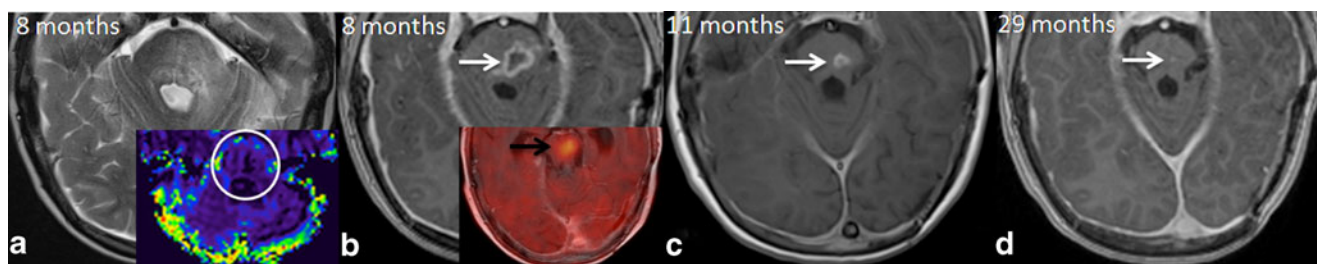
Follow-up MRI 8 months (a, b), 11 months (c), and 29 months (d) after beginning of complementary proton beam irradiation. a Axial T2-weighted showing an hyperintense lesion within the pons. b Axial T1-weighted after gadolinium showing appearance of abnormal rim-like enhancement (white arrow) with T2 hypersignal (a). The lesion
